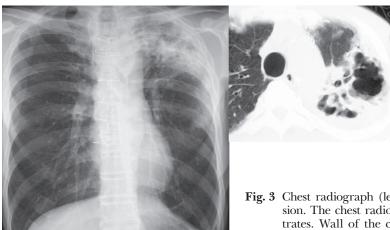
Chest radiograph (left) and CT (right) obtained on admission. The chest radiograph showed progression of the infiltrates. Wall of the cavities were indurated and the pleura became thicker.
